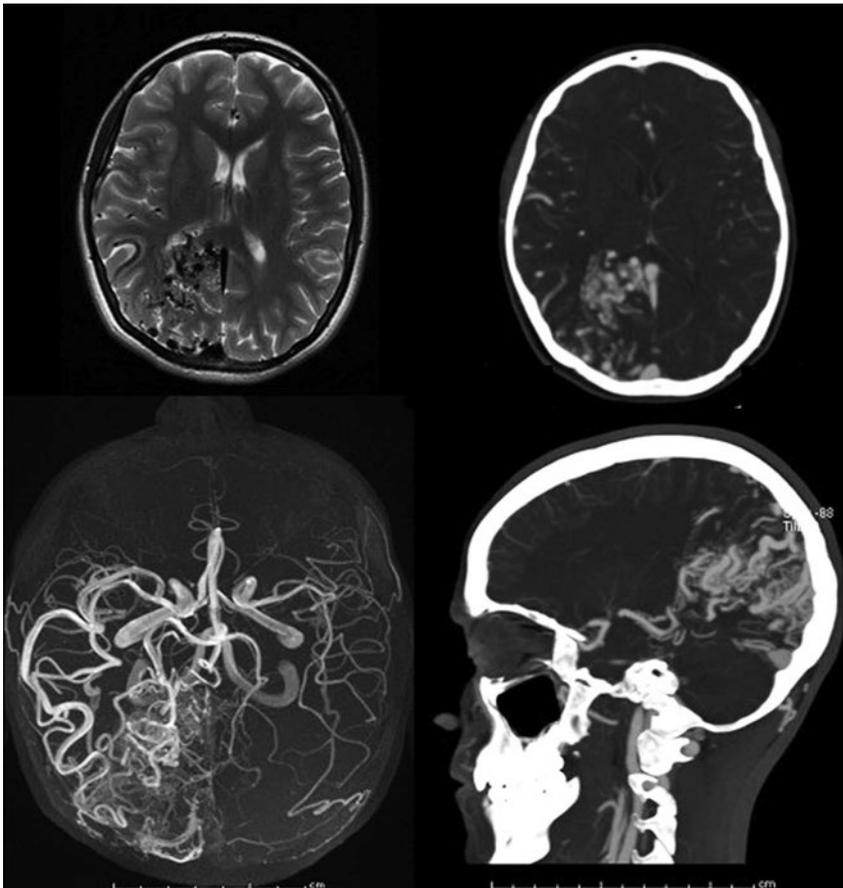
Characteristics of an arteriovenous malformation on magnetic resonance (MR) imaging and computed tomography (CT). Upper left: Axial T2 MR image with dark flow voids evident in the right occipital pole. Upper right: Same lesion detailed by CT angiography. Lower right: Sagittal view of the lesion, demonstrating a wedge-shaped configuration. Lower left: A collapsed MR angiogram.
